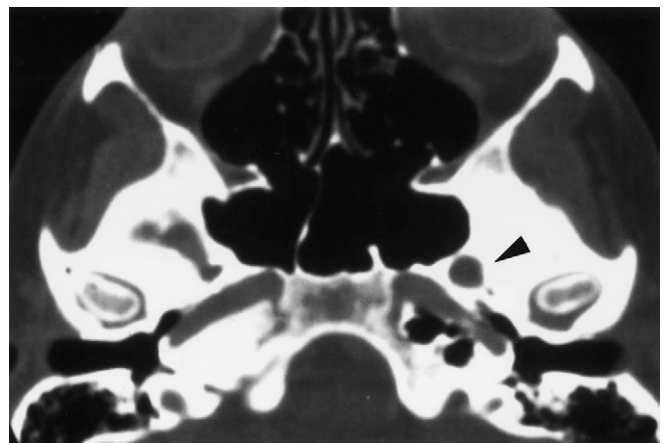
CT scan of 38-year-old woman with adenoid cystic carcinoma demonstrating perineural spread along V3 and widening of the foramen ovale (*arrowhead*). (Courtesy Dr. J. Netterville.)
